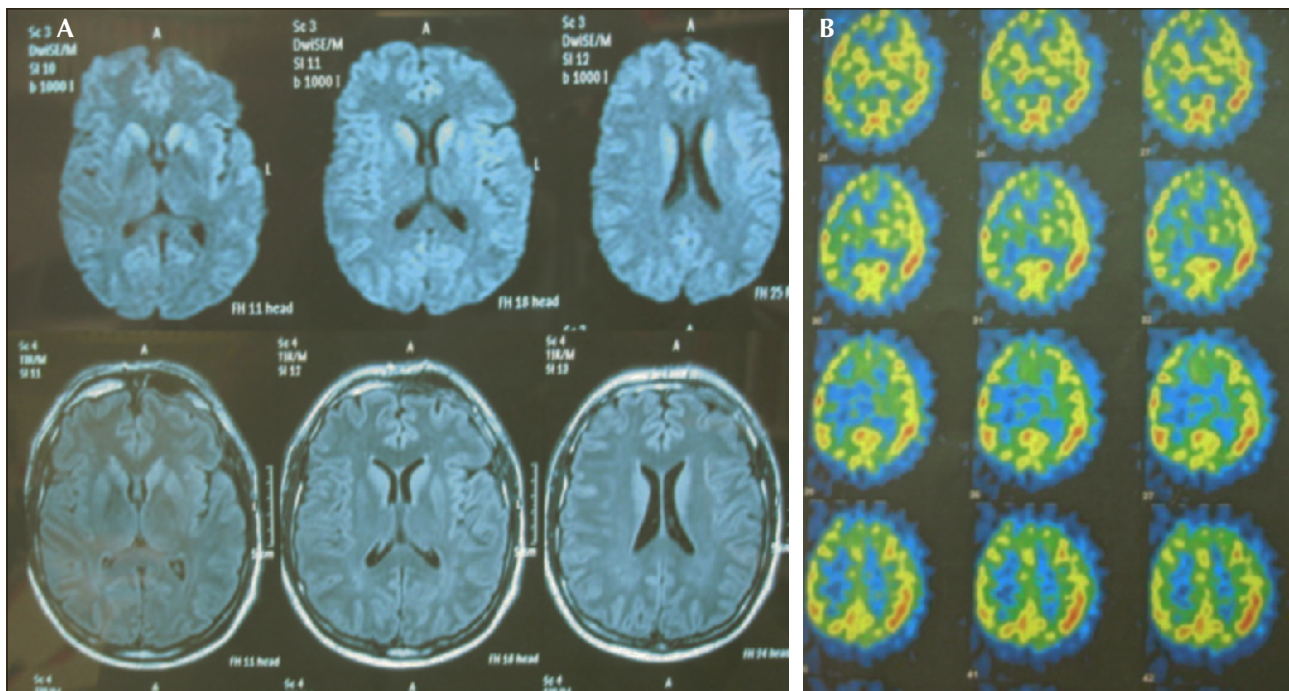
A) MRI (diffusion and FLAIR, axial section): hyperintensity areas in both caudate, lenticular nucleus and cortical areas. B) SPECT (axial section) day 18: severe cortical and cerebellar hypoperfusion.
